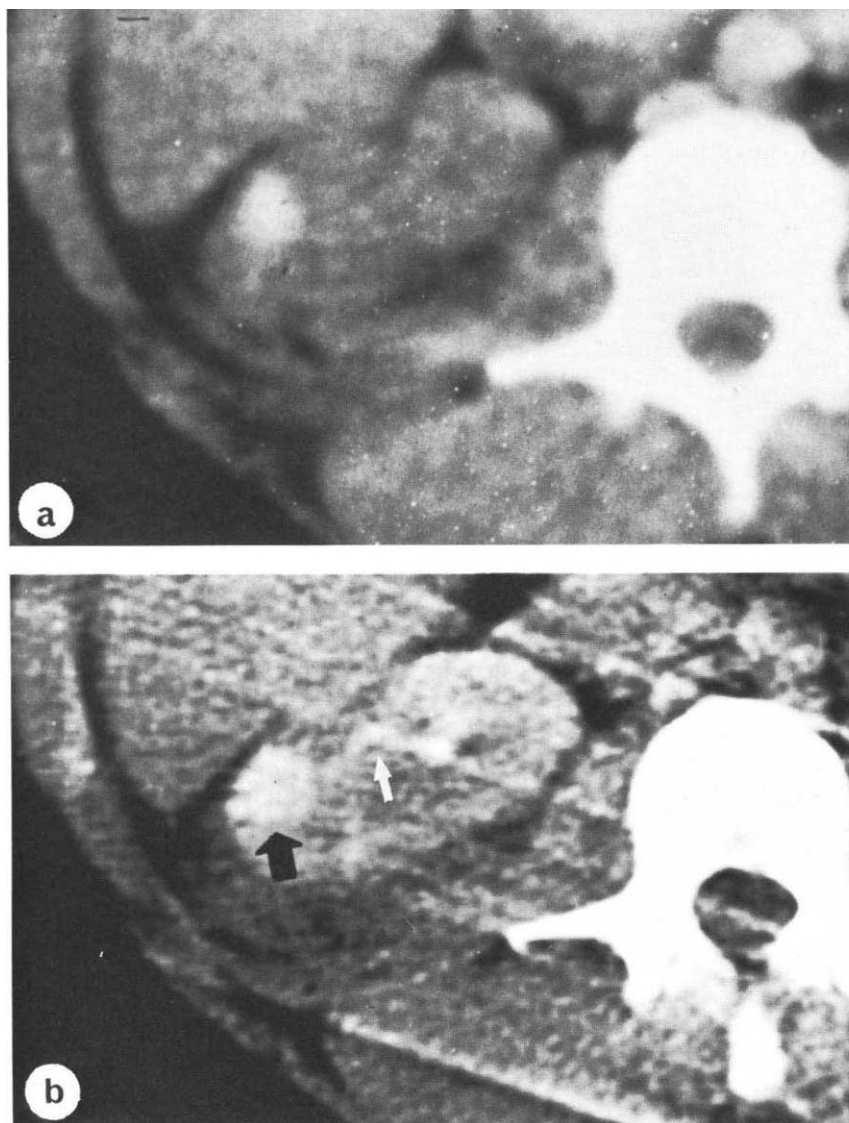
a) CT scan of the right kidney, showing a subcapsular collection of contrast medium from the previous days injection. Also present is a small perinephric hematoma. b) Detail view of the right kidney after injection of contrast medium the day after biopsy, showing intensification of the unusual concentration of contrast medium in the cortical parenchyma. In addition, there may be a communication (white arrows) between the renal collecting system and the cortical collection of contrast material (black arrows).
